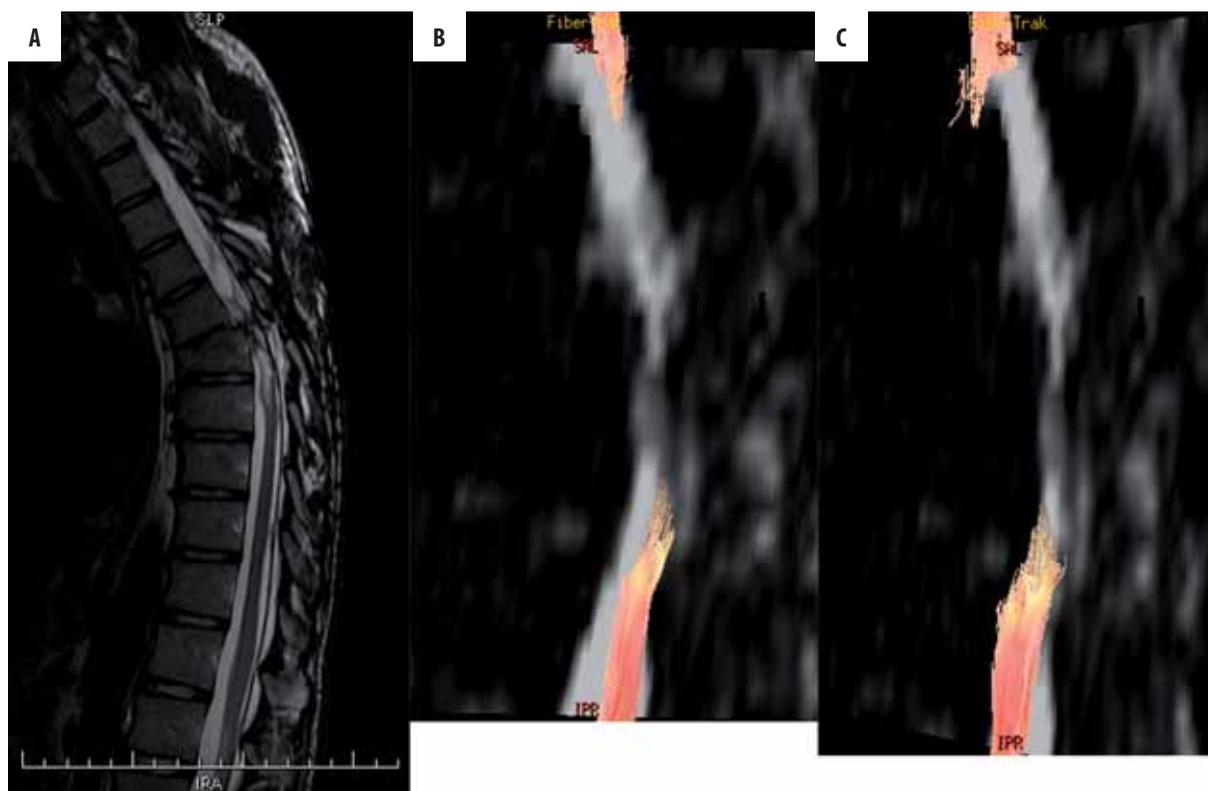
Severe traumatic injury of the spinal cord. MRI: the sagittal T2-weighted image (A) shows a large hyperintense area in the spinal cord, compatible with the damage. A diffusion tensor image (B) confirms complete long segment disruption of the white matter tracts. DTI after implementation of stem cells (C) reveals new white matter tracts in the upper part of the injury.
